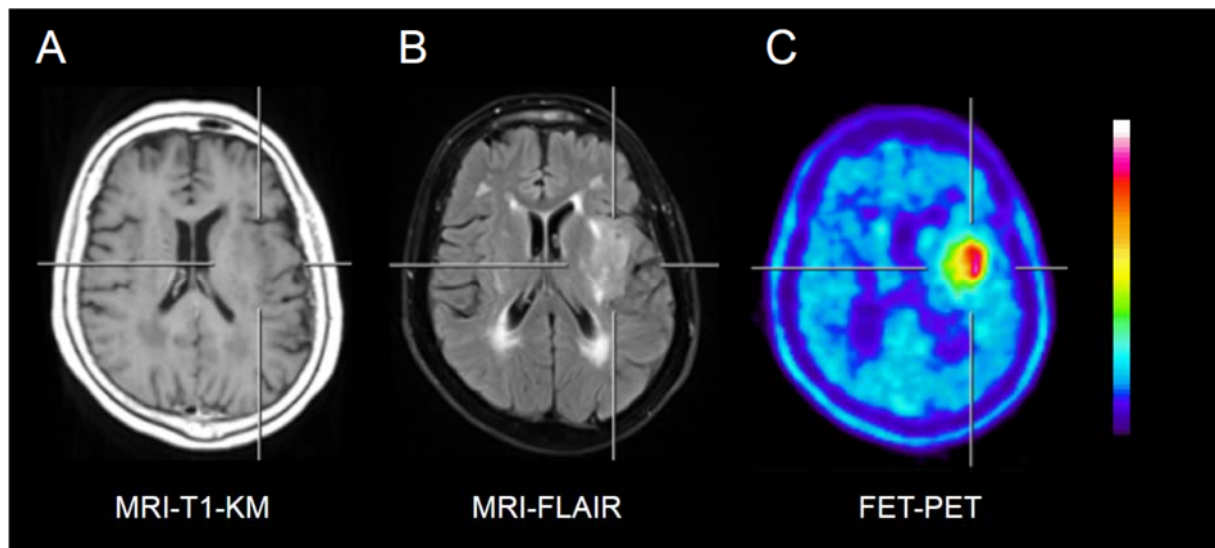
Patient with an anaplastic astrocytoma WHO Grade III. The true extent of the tumor and the metabolically most active tumor parts for biopsy guidance are difficult to identify in the contrast-enhanced T1-weighted (A) and in T2-weighted MRI (B) but clearly depicted in FET- PET (C).
